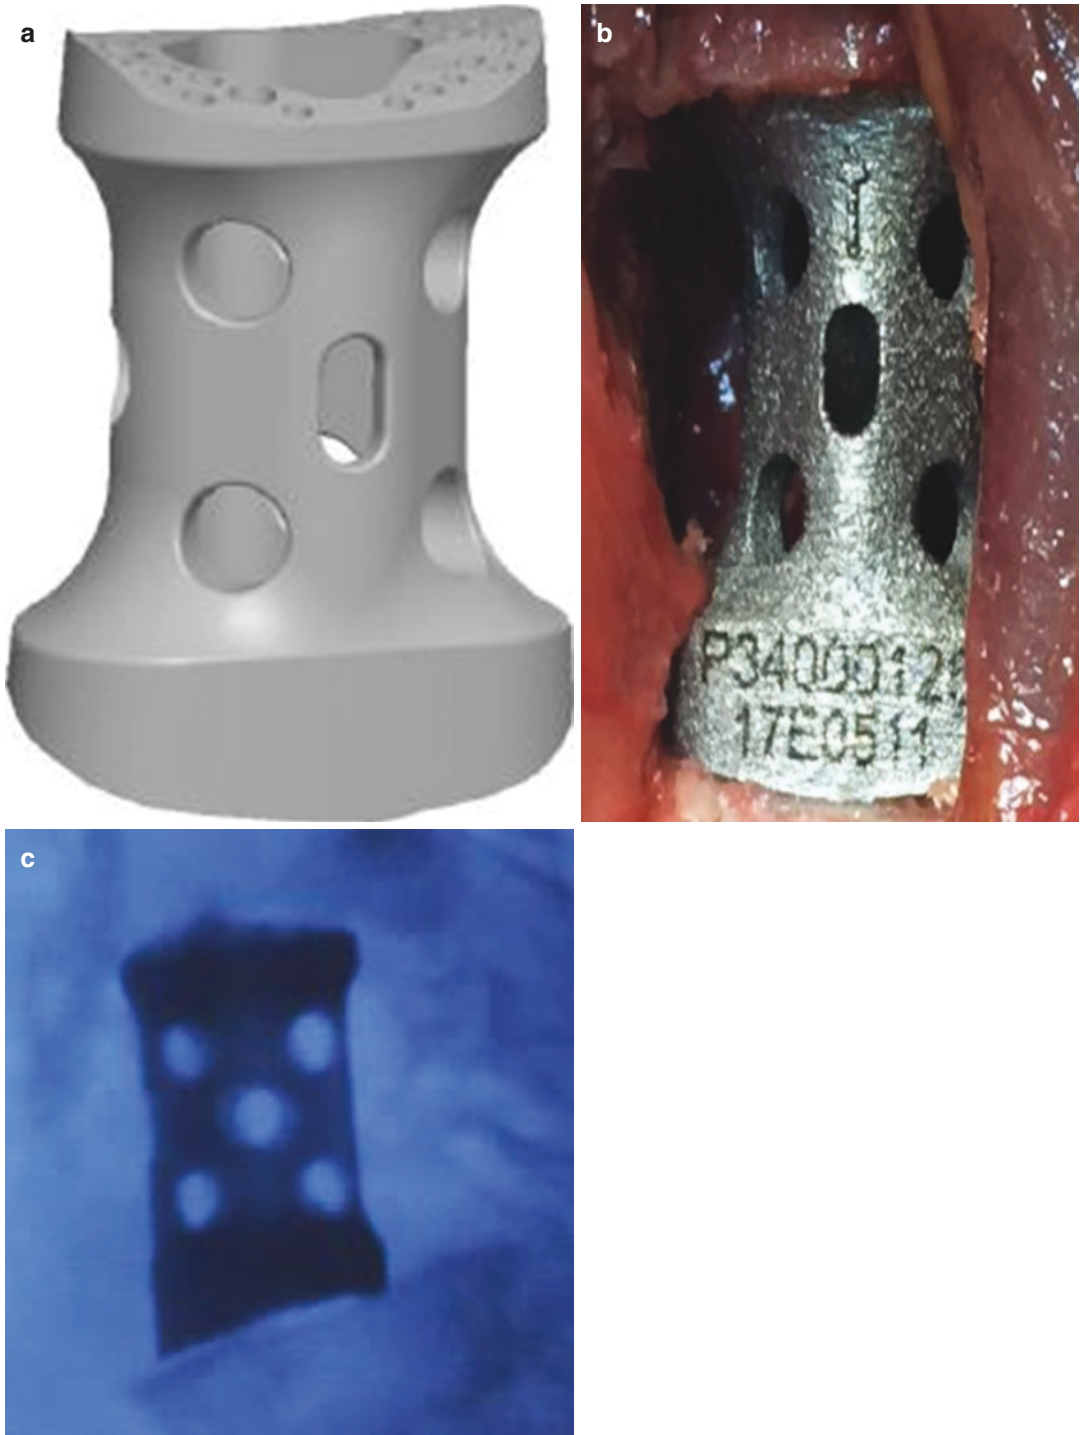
(a) Implant, (b) insertion of implant, and (c) lateral X-ray for confirmation
